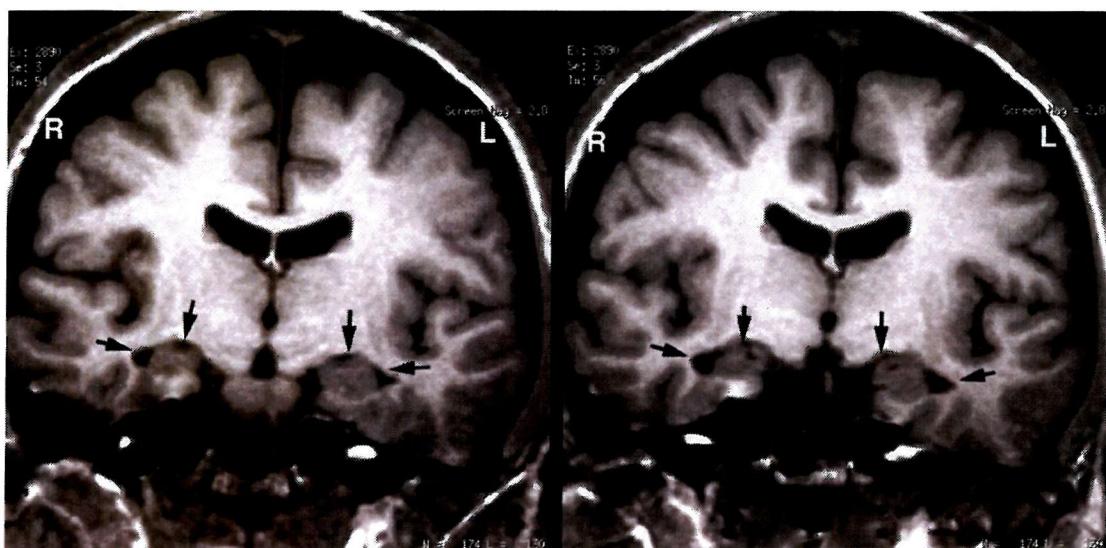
Coronal MRI images of HW's brain showing hippocampal atrophy in more posterior (Left) and more anterior (Right) cuts.
